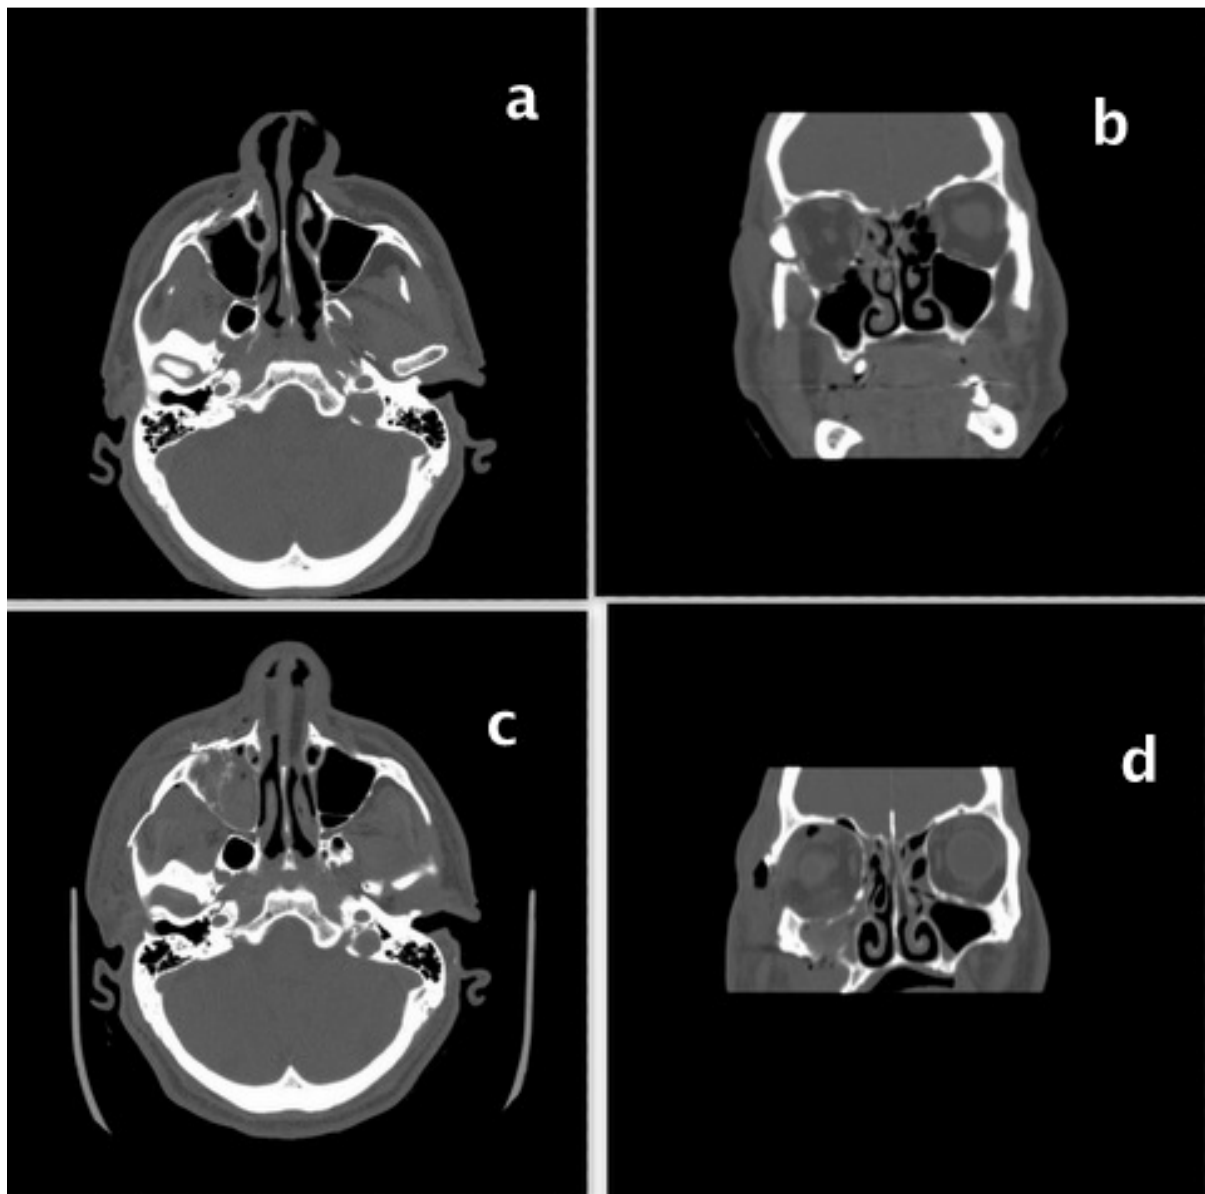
Computed tomography images of a patient with a dislocated zygomaticomaxillary complex fracture. (a, b) Preoperative images. (c, d) Images obtained after surgery using a combined transconjunctival (TC) and transoral maxillary approach and lateral rim skin incision, both without canthotomy, together with two fixation points.
